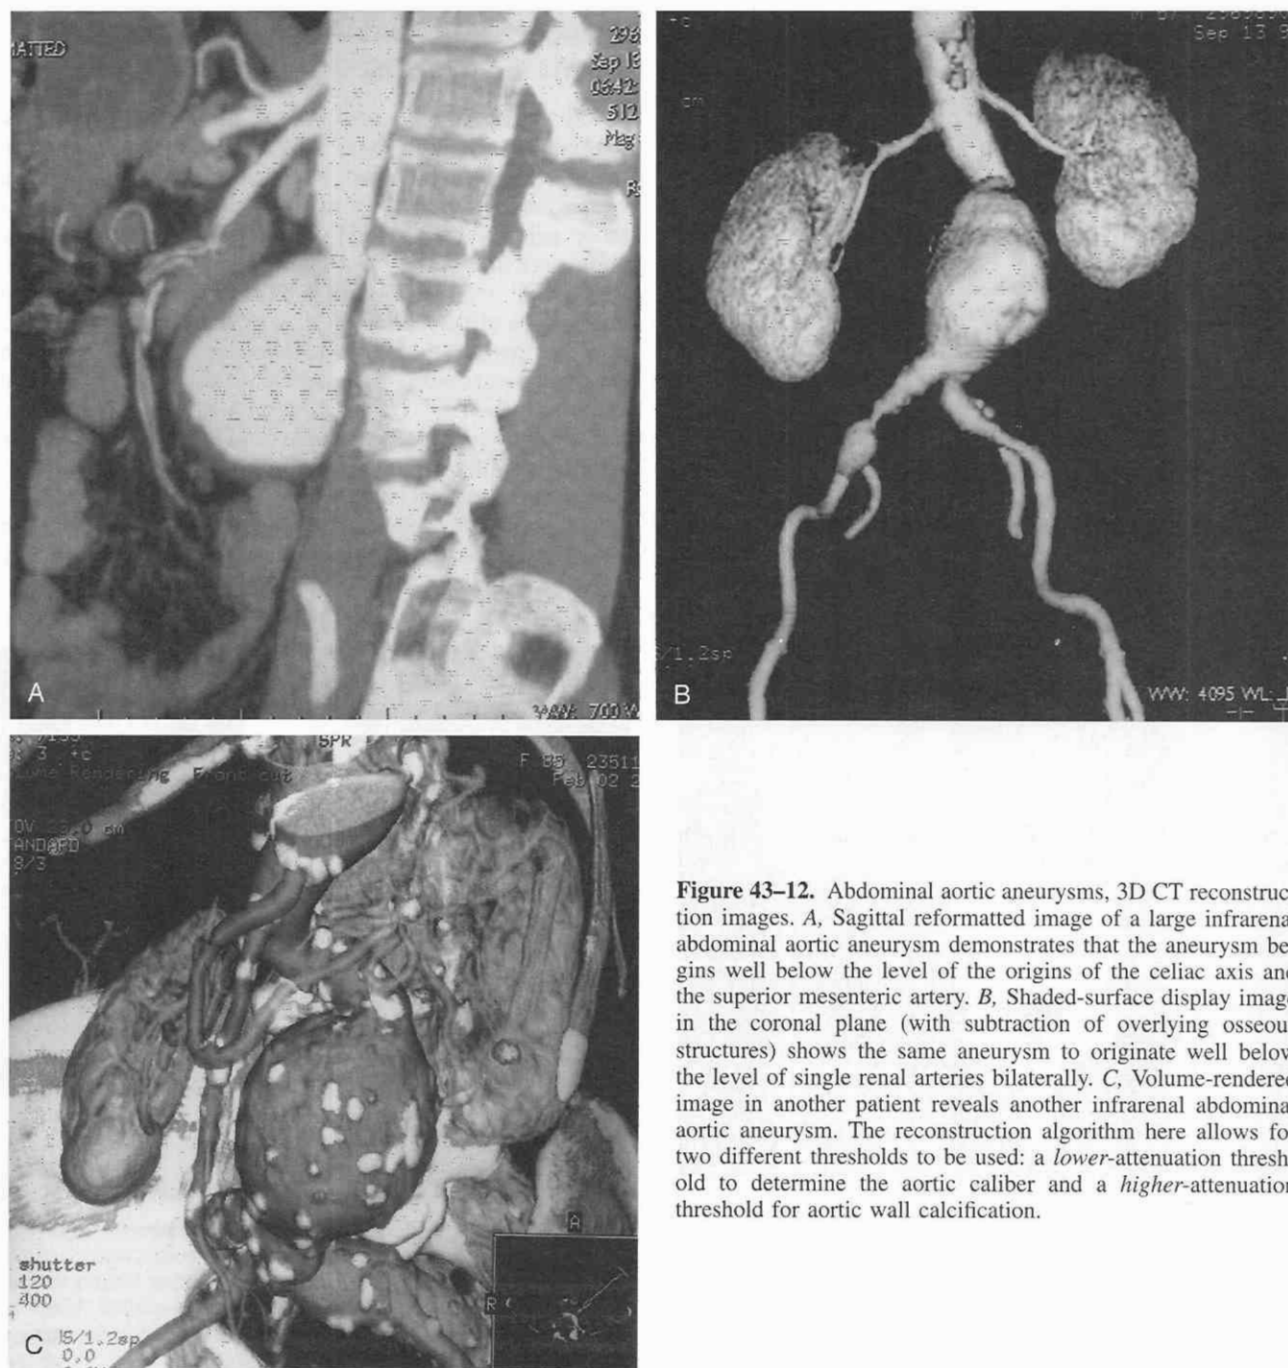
Abdominal aortic aneurysms, 3D CT reconstruction images. *A*, Sagittal reformatted image of a large infrarenal abdominal aortic aneurysm demonstrates that the aneurysm begins well below the level of the origins of the celiac axis and the superior mesenteric artery. *B*, Shaded-surface display image in the coronal plane (with subtraction of overlying osseous structures) shows the same aneurysm to originate well below the level of single renal arteries bilaterally. *C*, Volume-rendered image in another patient reveals another infrarenal abdominal aortic aneurysm. The reconstruction algorithm here allows for two different thresholds to be used: a *lower*-attenuation threshold to determine the aortic caliber and a *higher*-attenuation threshold for aortic wall calcification.
